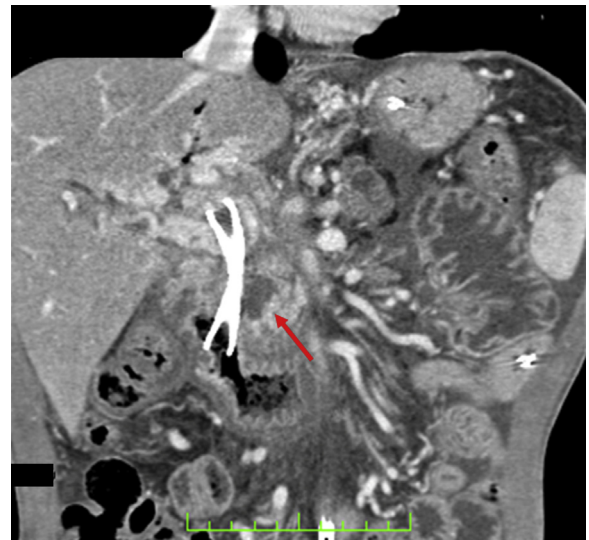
A delayed phase on CT showing the coagulation area (*red arrow*) adjacent the biliary metal stent, with a well-demarcated rim of postcontrast enhancement at 24 hours.
